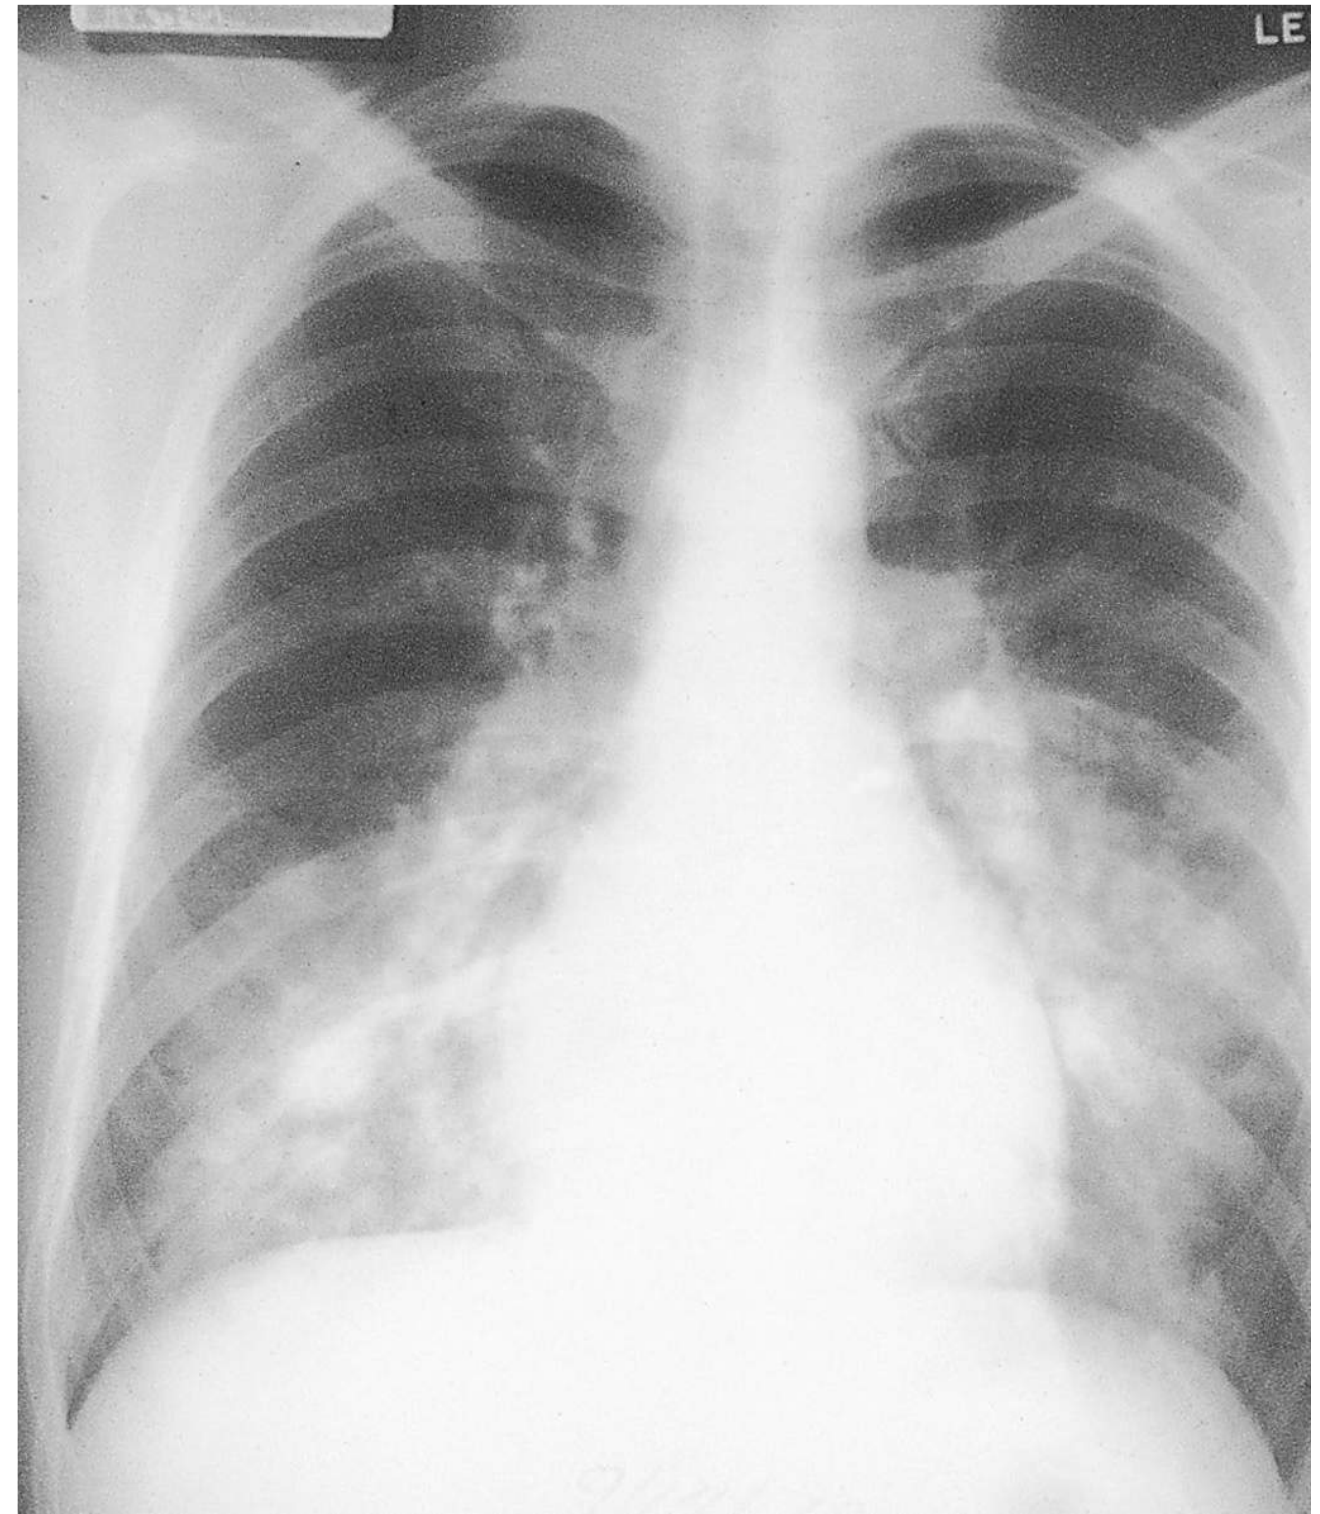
■ High-Altitude Pulmonary Edema. Chest x-ray in patient with HAPE. Note normal heart size with bilateral “patchy” pulmonary infiltrates. (Photo contributor: Peter Hackett, MD.)
